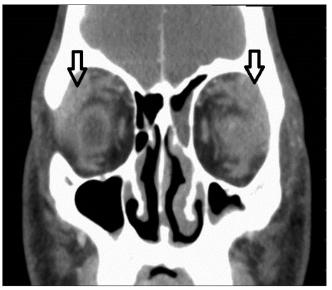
Coronal CT image showing bilateral lacrimal gland inflammation (arrows)
